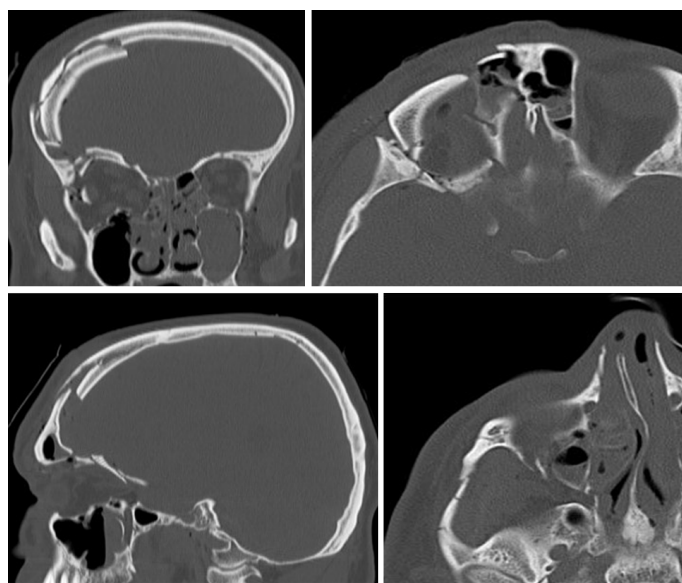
Initial polytrauma CT revealing a complex skull fracture
